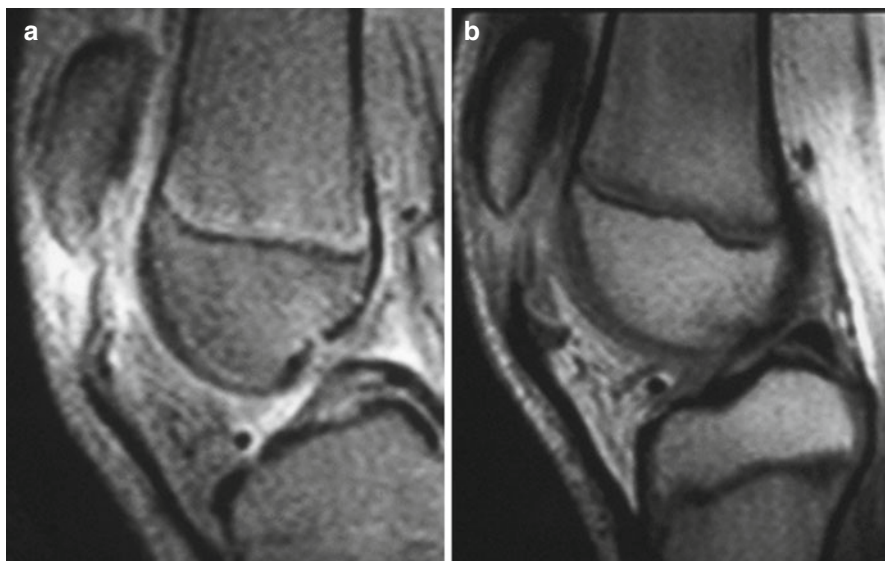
Isolated rupture of the patellar tendon at the level of the distal patellar pole. (a, b) IR and T1-weighted sequences on sagittal plane show tendon retraction with an inhomogeneous signal intensity and soft tissue swelling
